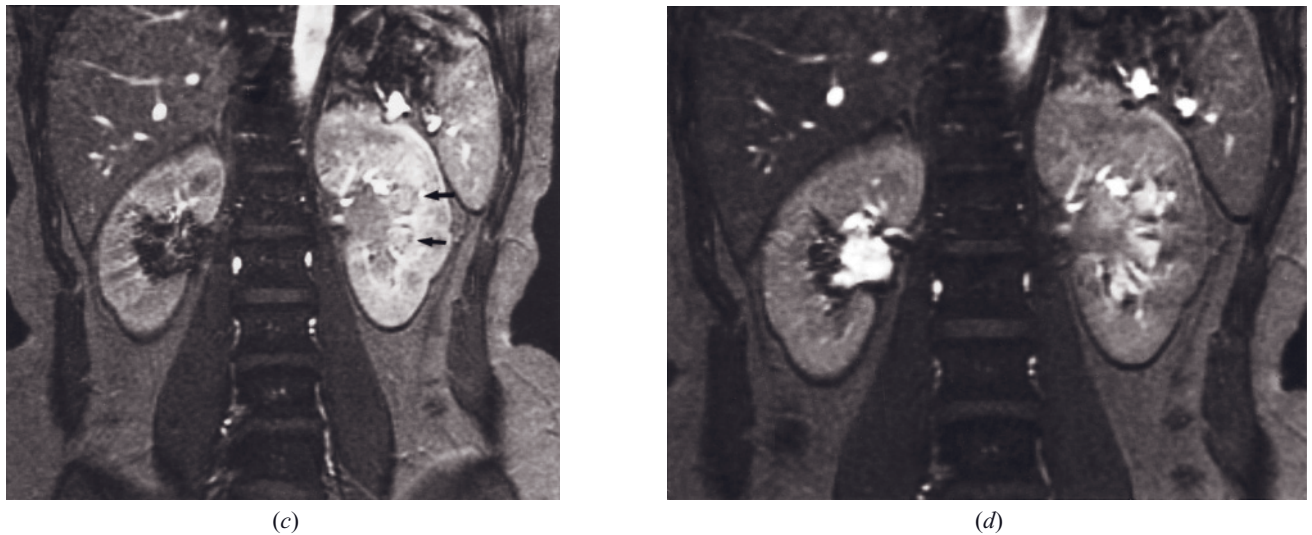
(Continued) image (c). The delayed image obtained at 3.5 min shows dilute (high signal intensity) urine in dilated calyces (arrows, c) of the left kidney. Concentrated (low signal intensity) urine is excreted from the right kidney. Excretory-phase image (d) obtained 15 min after injection. Dilute urine is excreted by the normal right kidney. Further excretion into the dilated left renal collecting system can be appreciated. (Reprinted with permission from Semelka RC, Hricak H, Tomei E, Floth A, Stoller M: Obstructive nephropathy: evaluation with dynamic Gd-DTPA enhanced MR imaging. *Radiology* 175: 797-803, 1990.)
